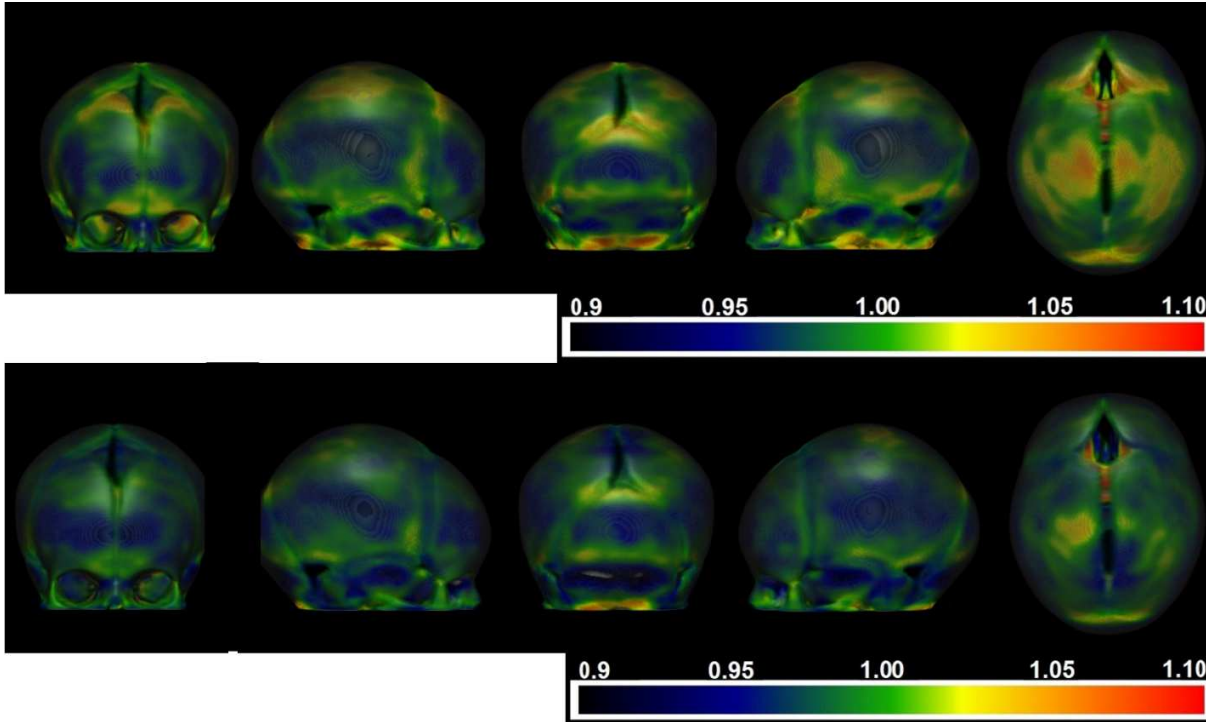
Local relative volume changes for subjects at 39-40 weeks GA (first row) and subjects at 41-42 weeks GA (second row) with respect to CT template at 39-42 weeks GA as a common coordinate system. Local relative volume changes in each row were calculated by averaging individual determinant of the Jacobian matrix. The Jacobian matrix field was derived from nonlinear deformation that warps each individual towards CT_{39-42} . The scale bar shows the determinant of the Jacobian matrix that is color coded to show regions of volume expansion ($|J| > 1$), volume shrinkage ($|J| < 1$) or no volume change ($|J| = 1$).
